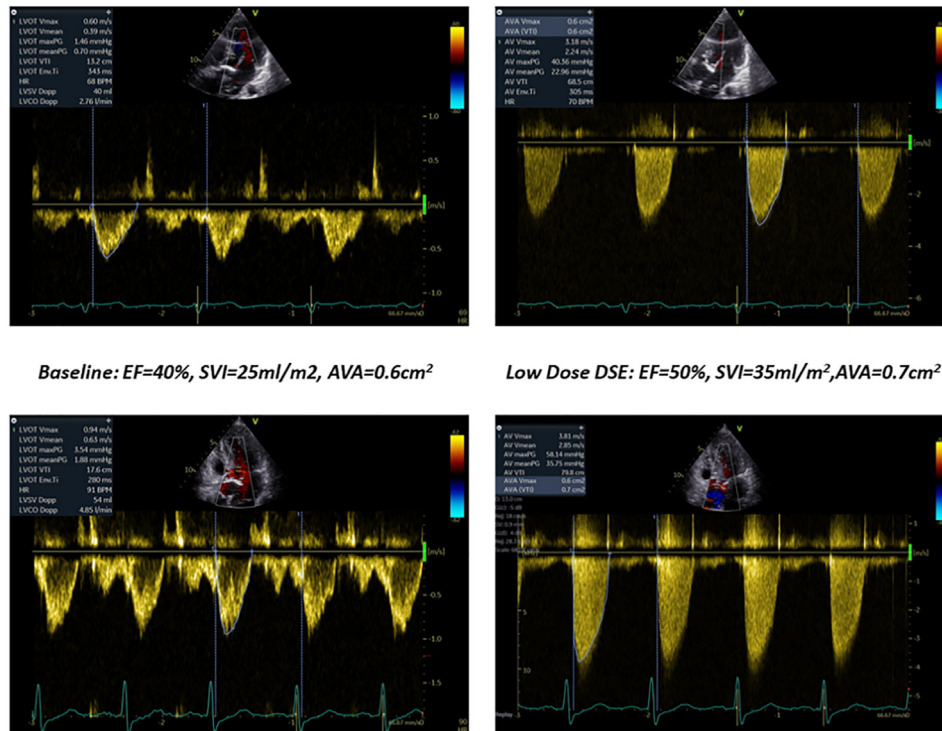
Low-dose dobutamine stress echocardiography in patients with LF/LG severe AS.
